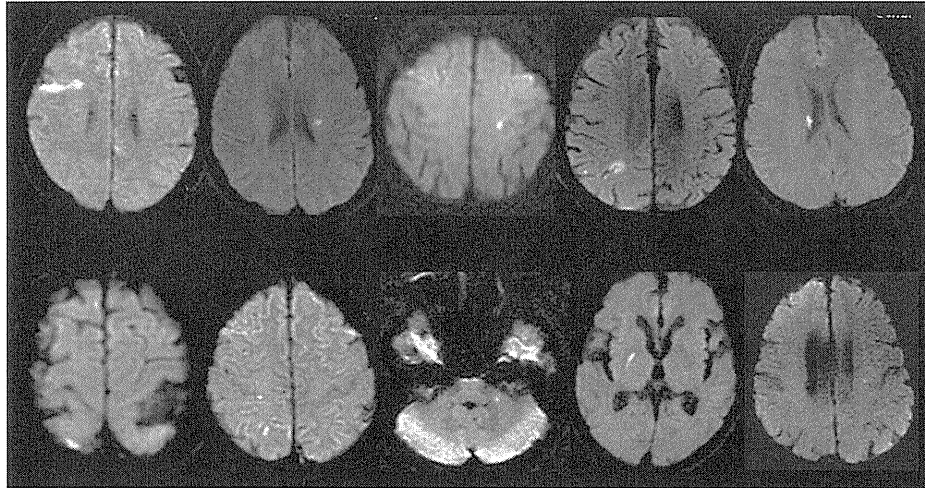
再検査 MRI により脳梗塞が検出された症例の拡散強調画像
